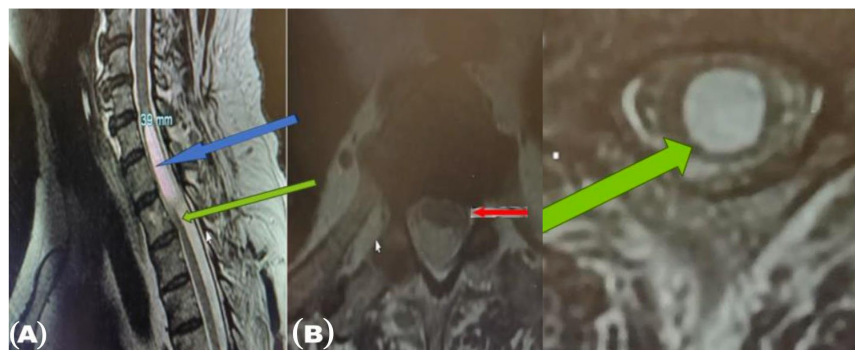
Preoperative T2 sagittal showing spinal cord deformation (scalpel sign, green arrow) and syringomyelic cavity “blue arrow” (A), and axial T1 view showing anterior displacement of the spinal cord (red arrow) (B). Axial T2-weighted image showing the syringomyelic cavity indicated by the green arrow.
